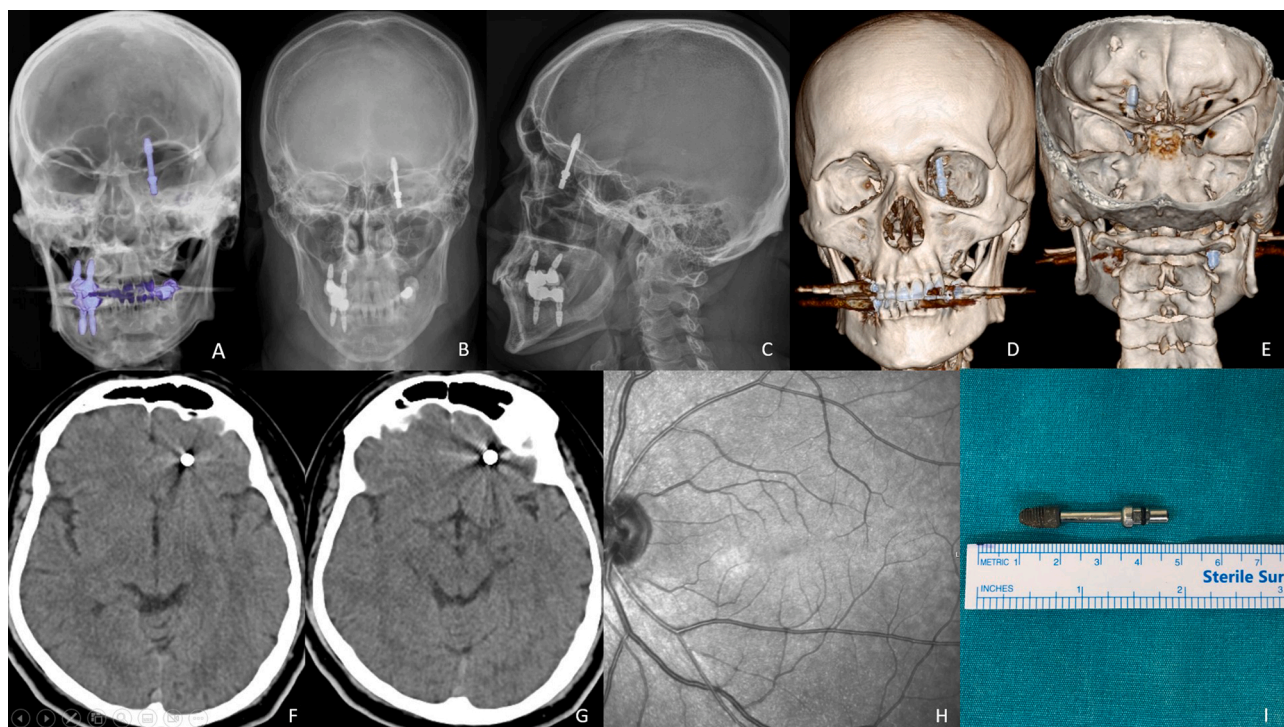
Preoperative anteroposterior (A, B) and lateral radiography (C); non-contrast cranial CT three-dimensional reconstruction anterior (D) and posterior (E) view images; preoperative non-contrast cranial CT axial images (F,G) of the patient show misplaced material in the frontobasal area. Preoperative optical coherence tomography result (H) of the patient were normal and no retinal damage or macular edema was detected. Intra-operative photograph (I) showing the misplaced implant material.
